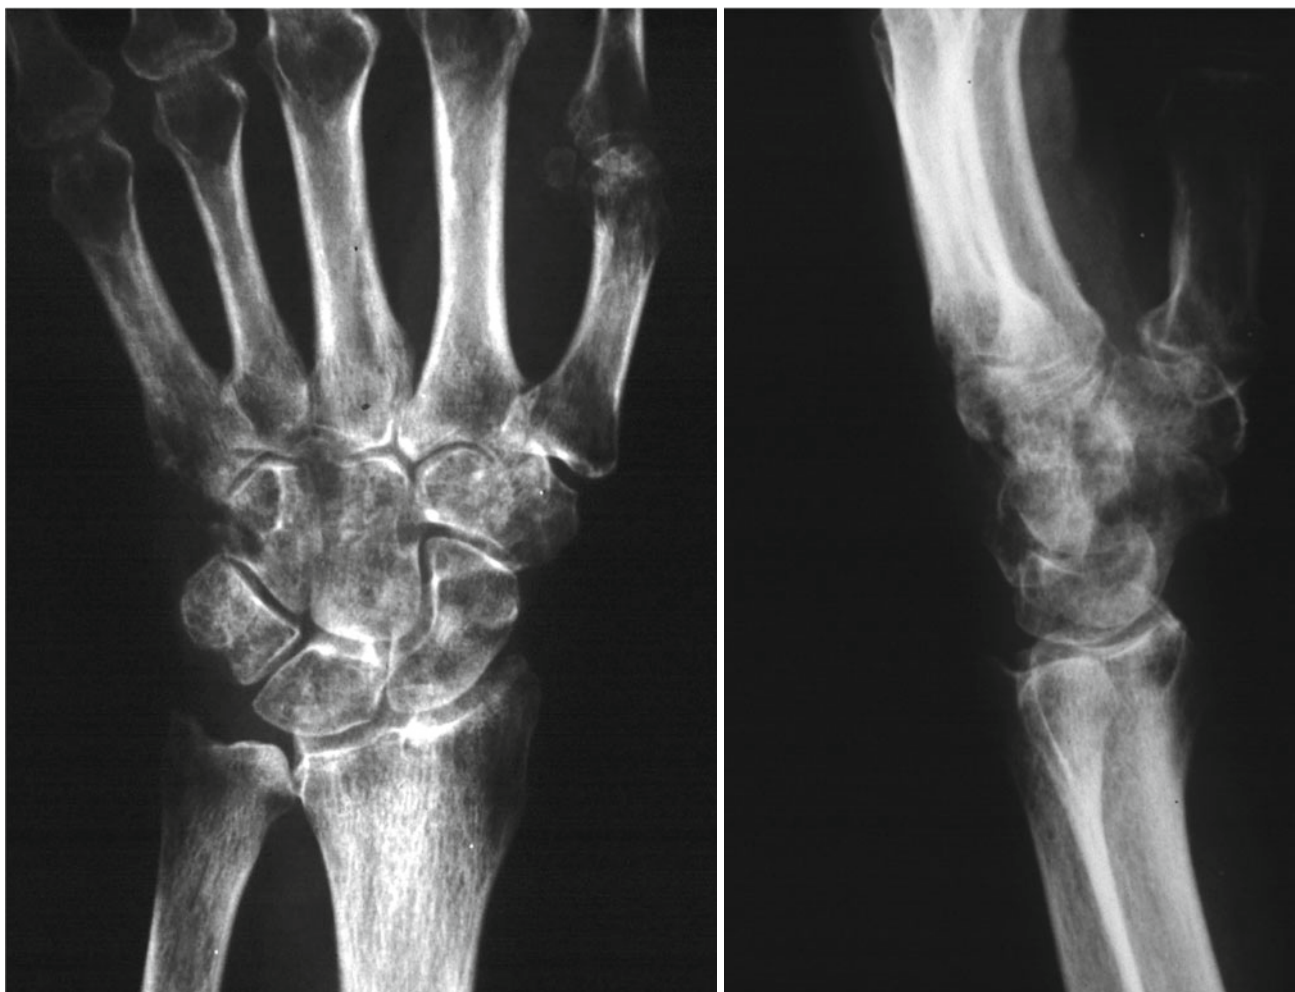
X-ray of the hands of a patient with long-standing polyradiculitis and poor recovery. Note the severe changes of osteoporosis
